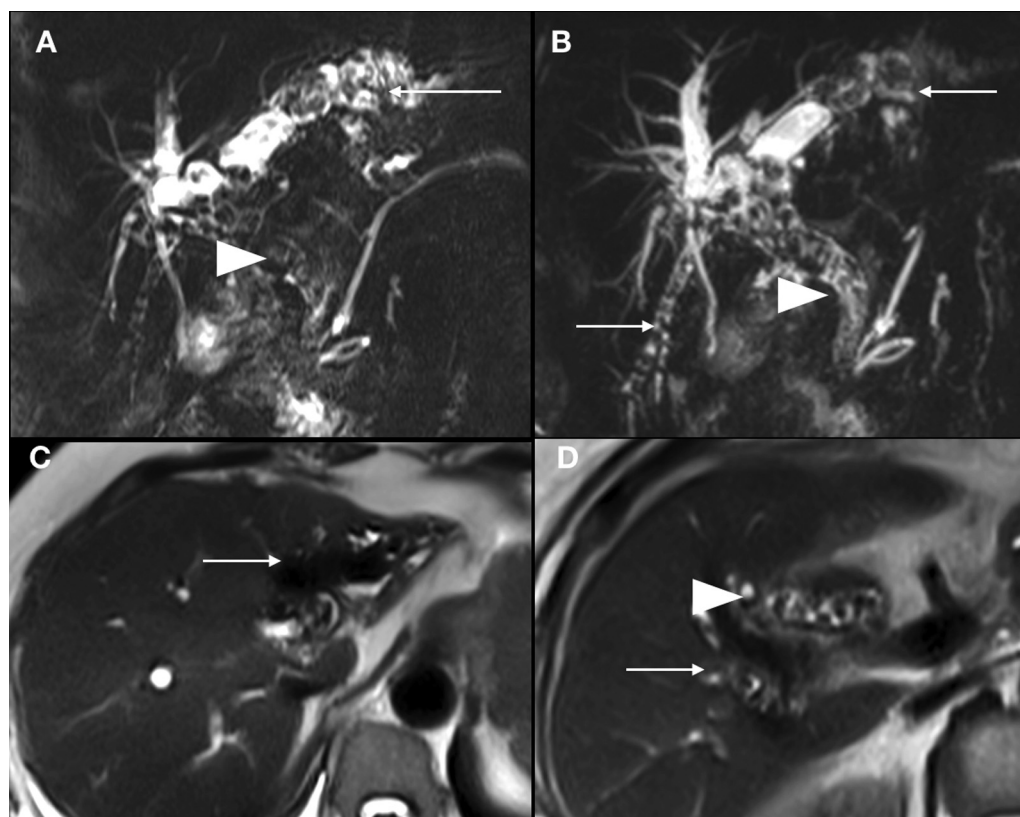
Coronal magnetic resonance cholangiopancreatography (MRCP) images (A, B) and T2-weighted (T2W) axial images (C, D) in a 38-year-old patient with jaundice showing markedly dilated biliary radicles showing hypointense filling defects suggestive of calculi in the dilated biliary radicles (white arrows) and in the dilated common bile duct (CBD) (white arrowheads). Findings are suggestive of recurrent pyogenic cholangitis.
